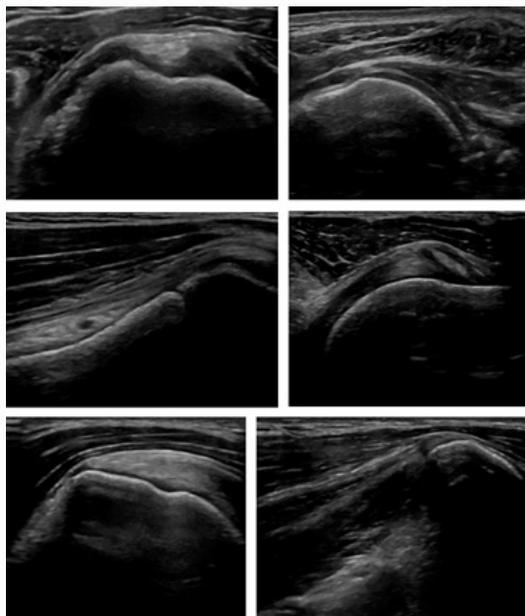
Sonographic scans of the soft tissue surrounding the shoulder joint.
